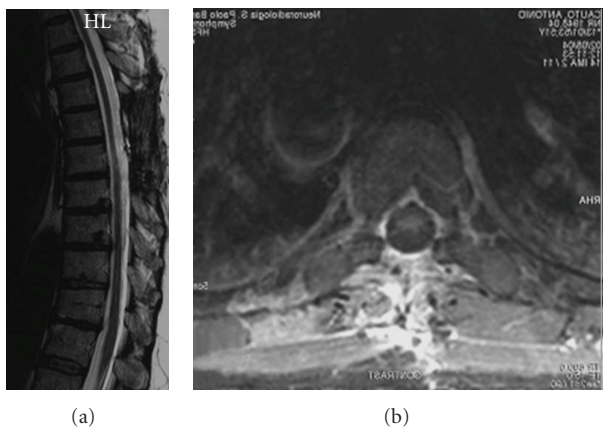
Postoperative MRI, performed 15 months after surgery, sagittal (a), and axial (b) sections: the spinal cord is totally decompressed and there is no evidence of arachnoidal cyst or syringomyelic cavity.
